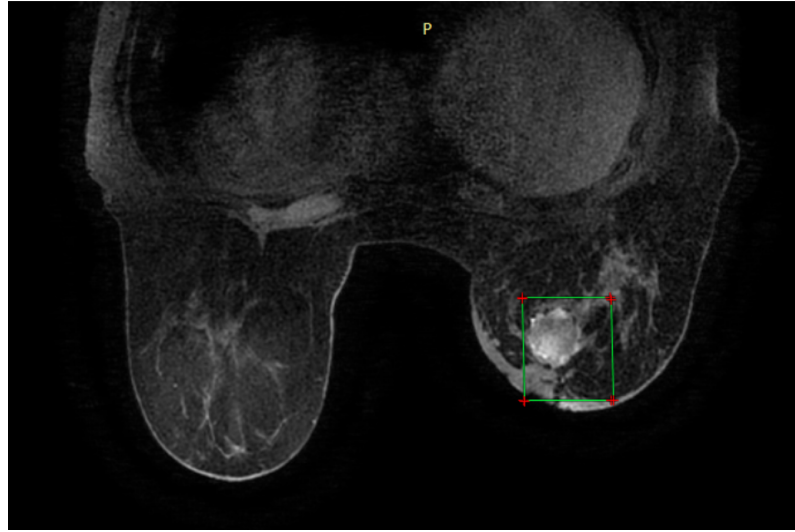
DICOM from MRI of breast cancer from patient with ID number 517 from dataset, with annotation of tumor.
